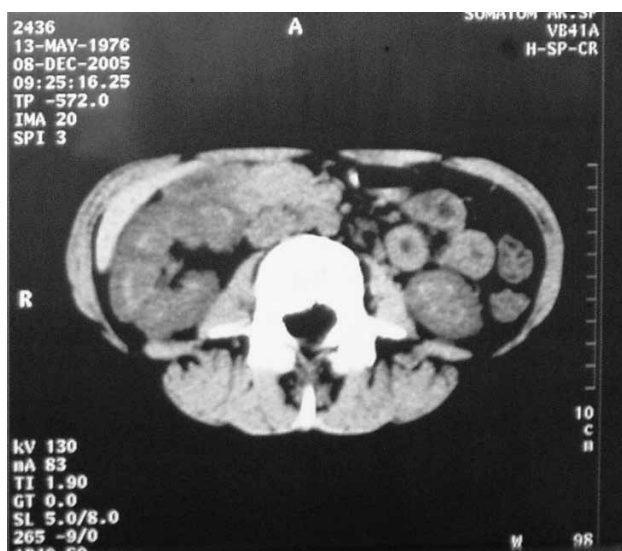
Kidney CT (normal shape, dimensions and position of kidney with distinct boundary. No concretions. No dilation of renal collecting system. Parenchymal structures density is non-homogenous, varies from 35 to 47 Hounsfield units.
